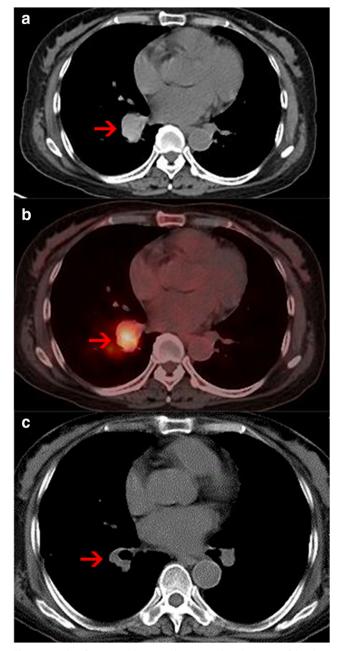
Imaging features. a Computed tomography (CT) scan of the chest showed dense consolidation in the right lung. b Positron emission tomography—computed tomography (PET/CT) scan showed a mass in the right lung with high-18F-fluorodeoxyglucose uptake. c After 5 cycles of treatment, chest CT scan revealed a reduction in the area of consolidation
